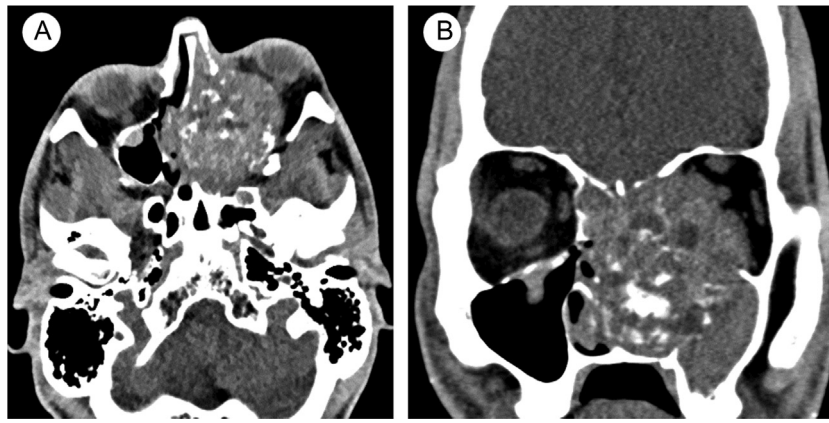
A. Adamantinoma-like Ewing sarcoma. There is a large expansile soft tissue mass with internal rings and arcs pattern mineralization. The mass is centered in the left nasal cavity and extends into the left maxillary sinus and left orbit, resulting in proptosis. Bone windows demonstrate extensive bony destruction. Axial CT. B. Adamantinoma-like Ewing sarcoma. The mass invades the right nasal cavity, ethmoid sinuses, left maxillary sinus, and left orbit, with lateral displacement of the medial and inferior rectus muscles, and abutment of the optic nerve. Bone windows demonstrate extensive bony destruction and thinning of the ethmoid roof. Coronal CT.
